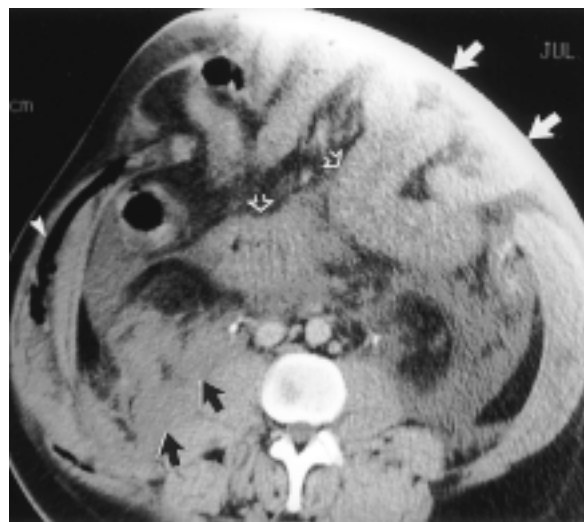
Multiple mesenteric and serosal jejunal tears in a 43-year-old man. CT scan shows thick-walled small-bowel loops (open arrows) that are partially obscured by an extraneous artifact (solid white arrows). The retroperitoneal hematoma (black arrows) is related to a renal laceration (not shown). Air between the internal and external oblique muscles (arrowhead) is related to barotrauma.
